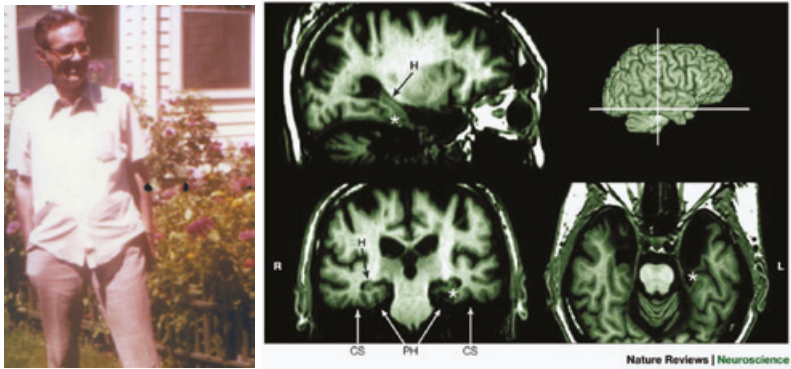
Left: Photograph of HM taken in 1975 (image from *Permanent Present Tense* by Suzanne Corkin. Copyright Suzanne Corkin, 2013, used by permission of The Wylie Agency (UK) Ltd. Right: MRI scan of HM's brain depicting the loss of tissue (Abbreviations: CS, collateral sulcus; EC, entorhinal cortex; H, hippocampus; L, left; PH, parahippocampal gyrus). Reprinted by permission from Macmillan Publishers Ltd: (Corkin S, 'What's new with the amnesic patient H.M.?', *Nature Reviews Neuroscience*, February 2002; 3[2]:153–60).
